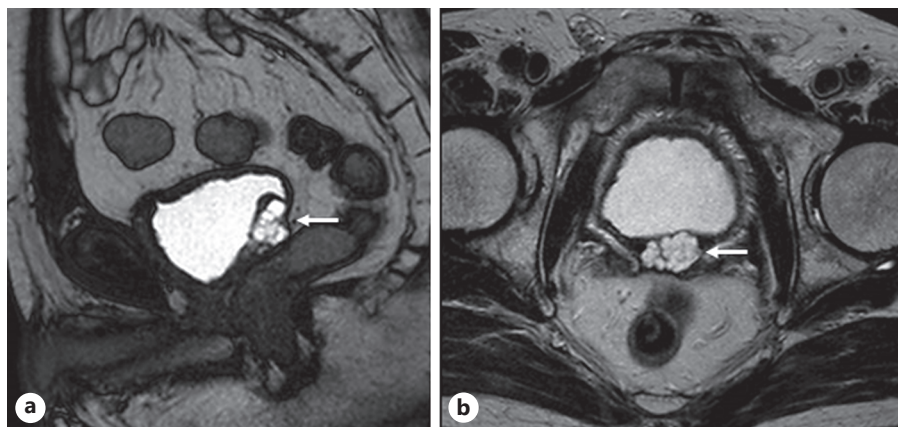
Postoperative MRI finding. a Sagittal and b axial MRI 8 months after the operation showed a 14 × 20 × 18 mm vesical multilocular cyst (arrow), suggesting local recurrence.
